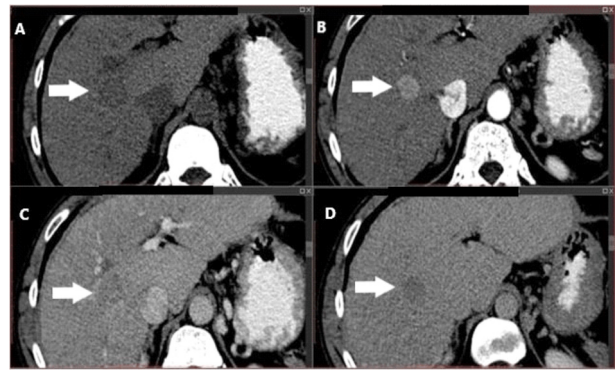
62-year-old man with unifocal HCC: (A) Native, non-enhanced CT; (B) Arterial enhancing nodule; (C) Portal venous phase; (D) Washout of contrast seen in the delayed venous phase. HCC: Hepatocellular carcinoma; CT: Computed tomography.
